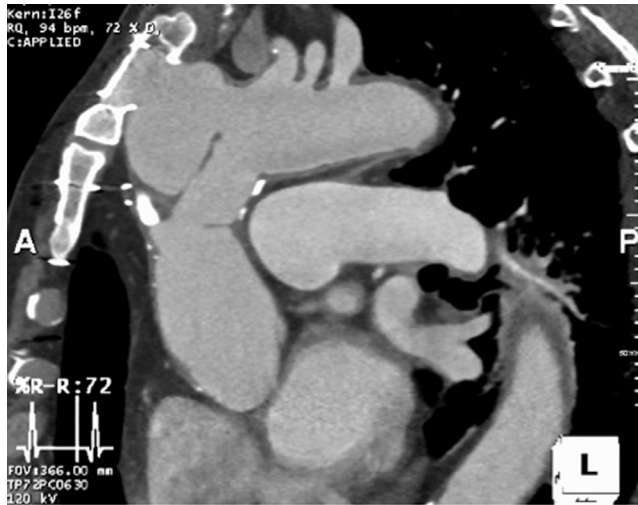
Pre-operative contrast-enhanced CT scan of the ascending aortic pseudoaneurysm.
